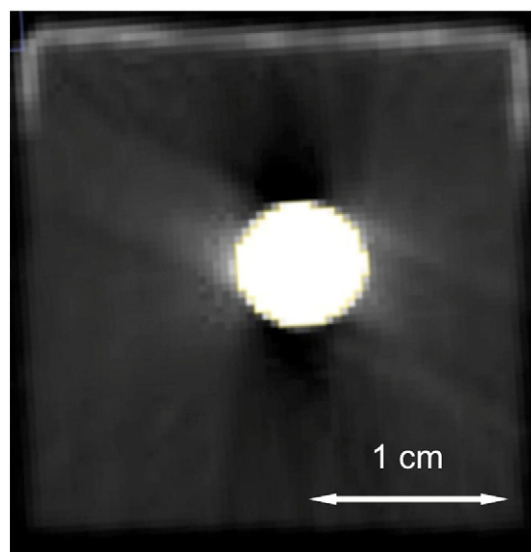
A cross-sectional image obtained from a CT scan used in the present work. Only the purely white pixels at the implant site were considered part of the surgical site area.
